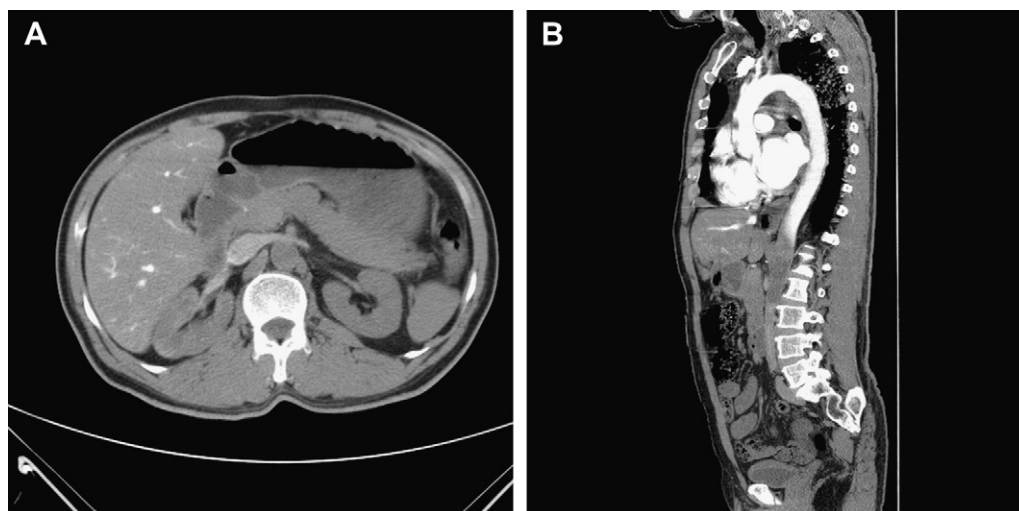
Occlusion of proximal abdominal aorta viewed by multidetector computed tomography (CT). (A) Axial CT image showed no enhancement of abdominal aorta at the level of liver; (B) sagittal reformatted image showed complete occlusion of the aorta at the level of T12.
